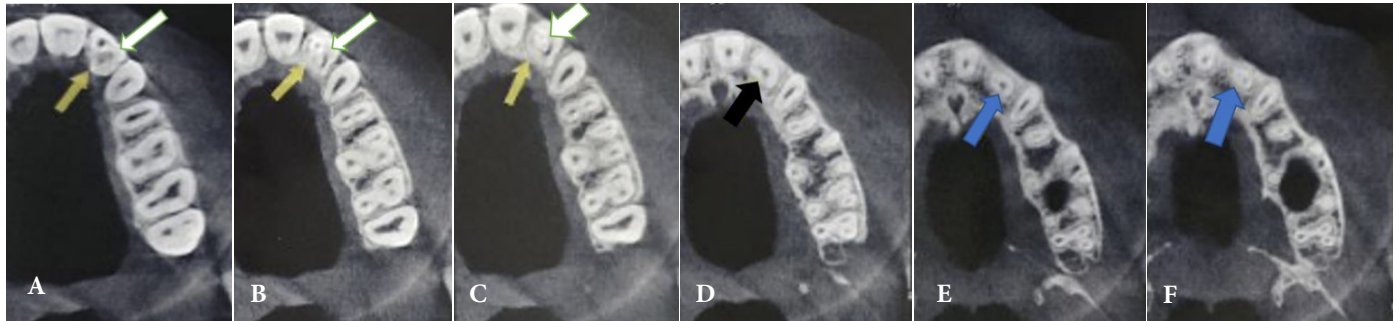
Sequential axial CBCT sections of the affected maxillary lateral incisor: A–F) represent consecutive axial slices from the coronal to the apical direction. Yellow arrows indicate the dens invaginatus (DI), and white arrows indicate the main canal (MC). The black arrow highlights the level at which the invaginated space and the main canal show their closest anatomical relationship. Blue arrows demonstrate apical bifurcation of the root canal system in the apical third
